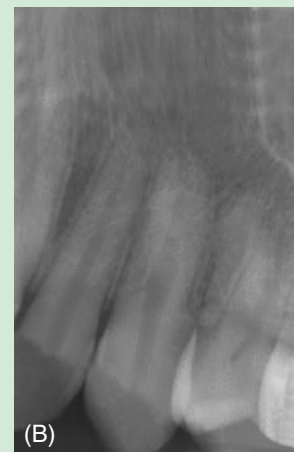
The patient at the end of the treatment. The transplanted tooth #6 is vital (A). Control X-ray (B). A very good balance and good esthetics are achieved.
